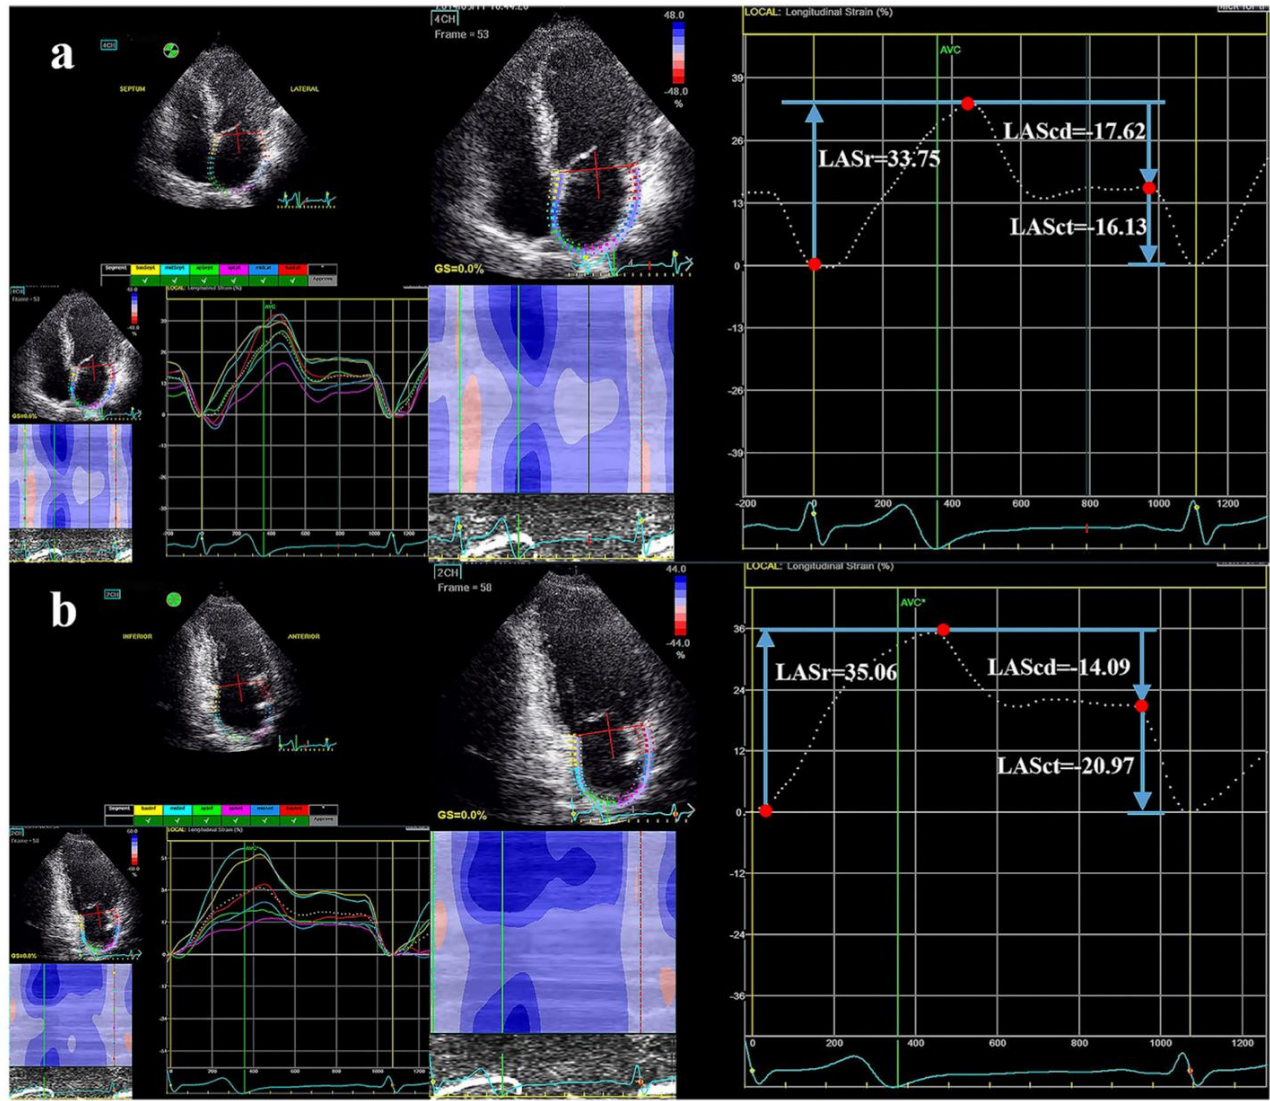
Two-dimensional transthoracic echocardiographic images showing measurement of phasic left atrial (LA) strain by speckle tracking echocardiography. a= Phasic LA strain measurement in apical 4 chamber view, b= Phasic LA strain measurement in apical 2 chamber view. LAS-r= LA reservoir strain, LAS-cd= LA conduit strain, LAS-ct= LA contractile strain. Reproduced from Lin et al, 2020 (reference # 10) with permission from Dr. Weichun Wu, corresponding author and no copyright permission required under CC BY 4 from publisher.
